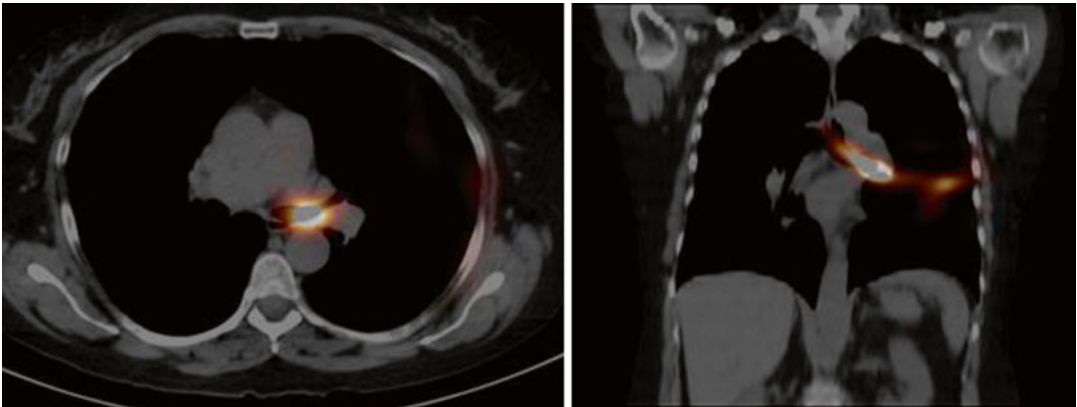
Transverse and sagittal fused SPECT/CT images of an NSCLC in the LUL. A is a sentinel lymph node in the left supra-hilar area and B is the injection site (Reproduced with permission (10.1007/s12149-014-0821-1))
